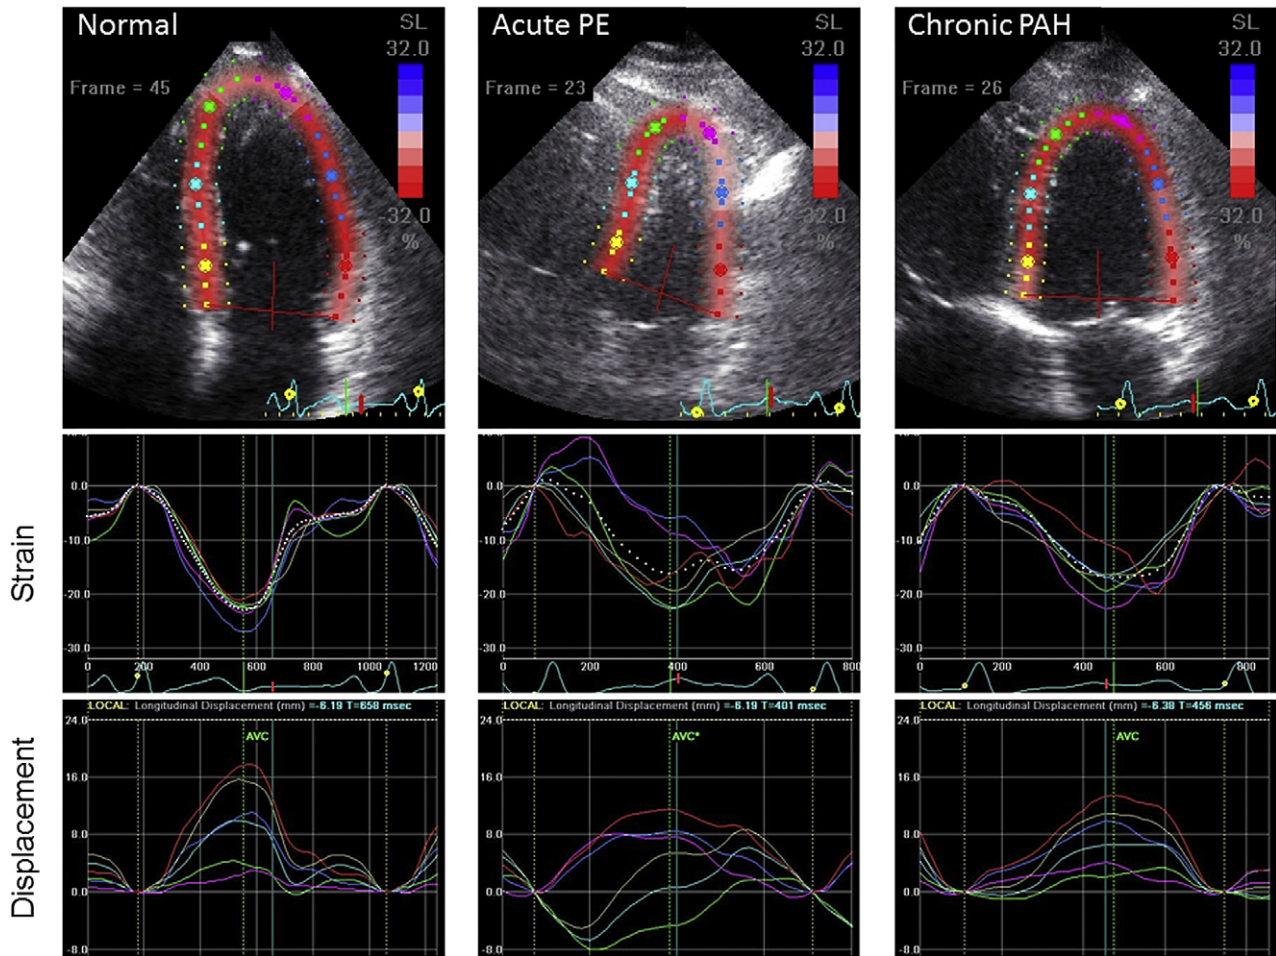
Examples of LV longitudinal strain imaging in the LV-focused apical four-chamber view (top) and corresponding time-strain (middle) and time-displacement (bottom) curves from the same normal subject (left), the same patient with massive APTE (middle), and the same patient with severe CPAH (right) as shown in Figure 2.
